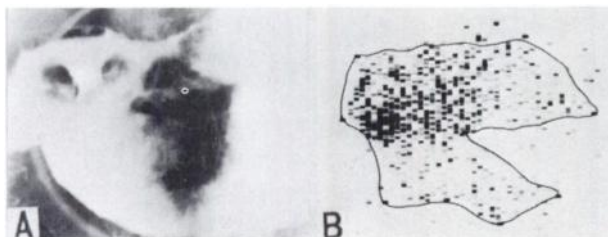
(A) X-ray shows multiple defects in antrum region of stomach. (B) Scintigram is slightly positive in resected stomach.
